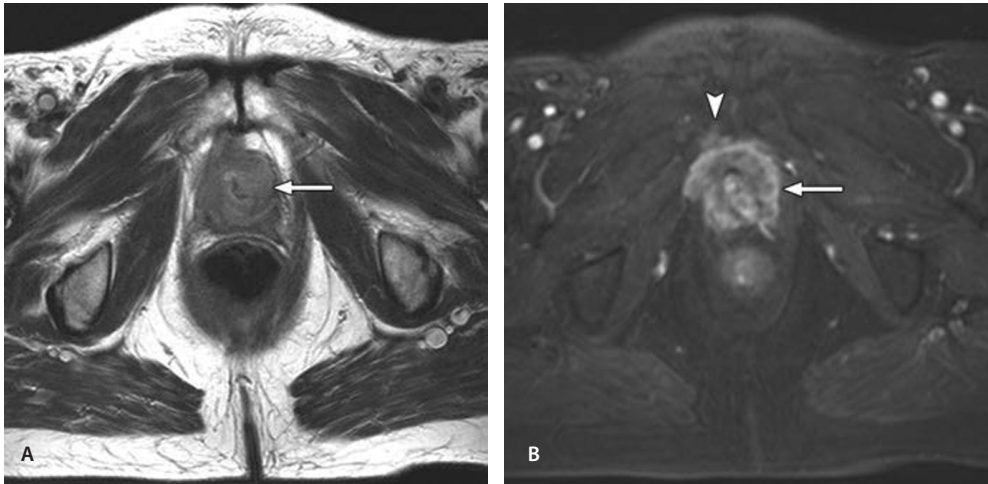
56-year-old woman with initial symptoms of painful and obstructive urinary flow. Imaging took place almost 6 weeks after surgical intervention in another hospital because of urethral stenosis with proven squamous cell carcinoma, probably arising within urethral diverticulum. Symptoms at time of imaging were fast-growing extremely painful mass at urethral meatus and vaginal wall. A and B, Axial T2-weighted 1.5-T image with pelvic coil (A) and axial T1-weighted image with fat saturation after IV administration of gadolinium chelate (B) show locally advanced tumor of distal urethra extending to os pubis on right (arrow). Gadolinium-enhanced image (B) reveals invasion of right pubic bone (arrowhead), finding that is not clear on A.
